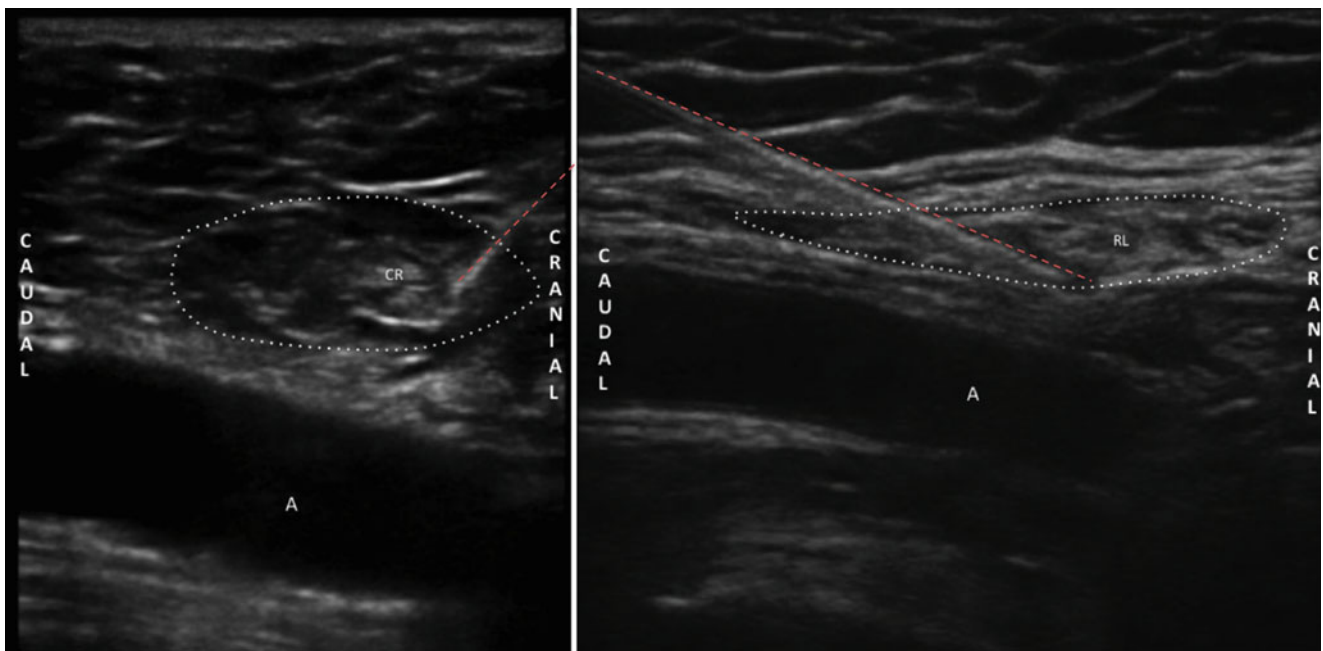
Genitofemoral ultrasound-guided injection. 1 Injection of the male internal inguinal ring filled with local anesthetic and needle tip near the cremaster. White dotted line represents the internal inguinal ring; dashed red line represents the needle path; CR cremaster, A external iliac artery. 2 Injection of the female internal inguinal ring
